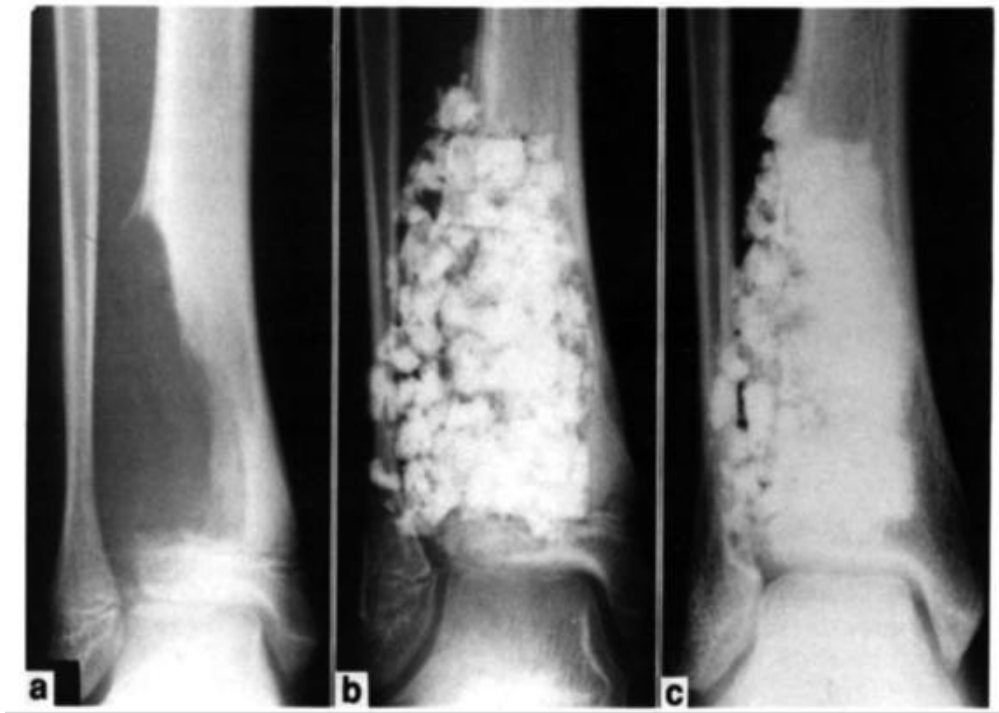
Series of radiographs showing bone development after removal of a giant cell tumor at the distal end of the tibia. a) Before surgery. b) Immediately after surgery. Visible are the hydroxyapatite granules packed into the void left by tumor removal. c) 3 years after surgery [32].
